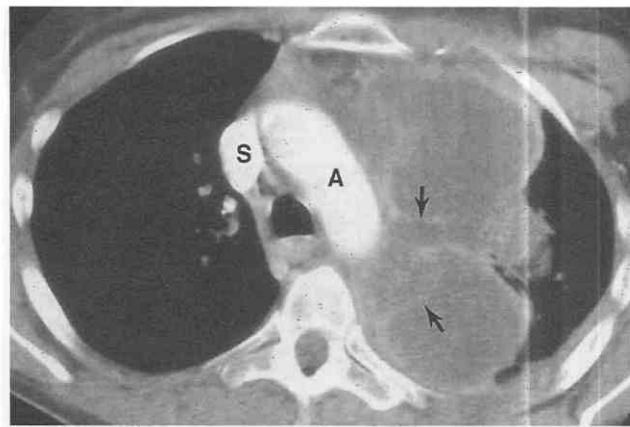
Mediastinal liposarcoma. Contrast-enhanced CT shows a large heterogeneous mediastinal mass involving multiple compartments. Note enhancing septa (arrows) and absence of adipose tissue within mass. A, aorta; S, superior vena cava.
